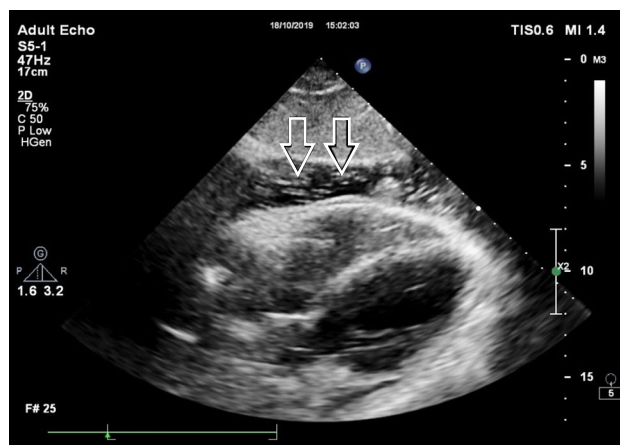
Two-dimensional echocardiography revealing several tiny sparkling echogenic spots swirling in the pericardial sac evoking micro air bubbles (arrows).
